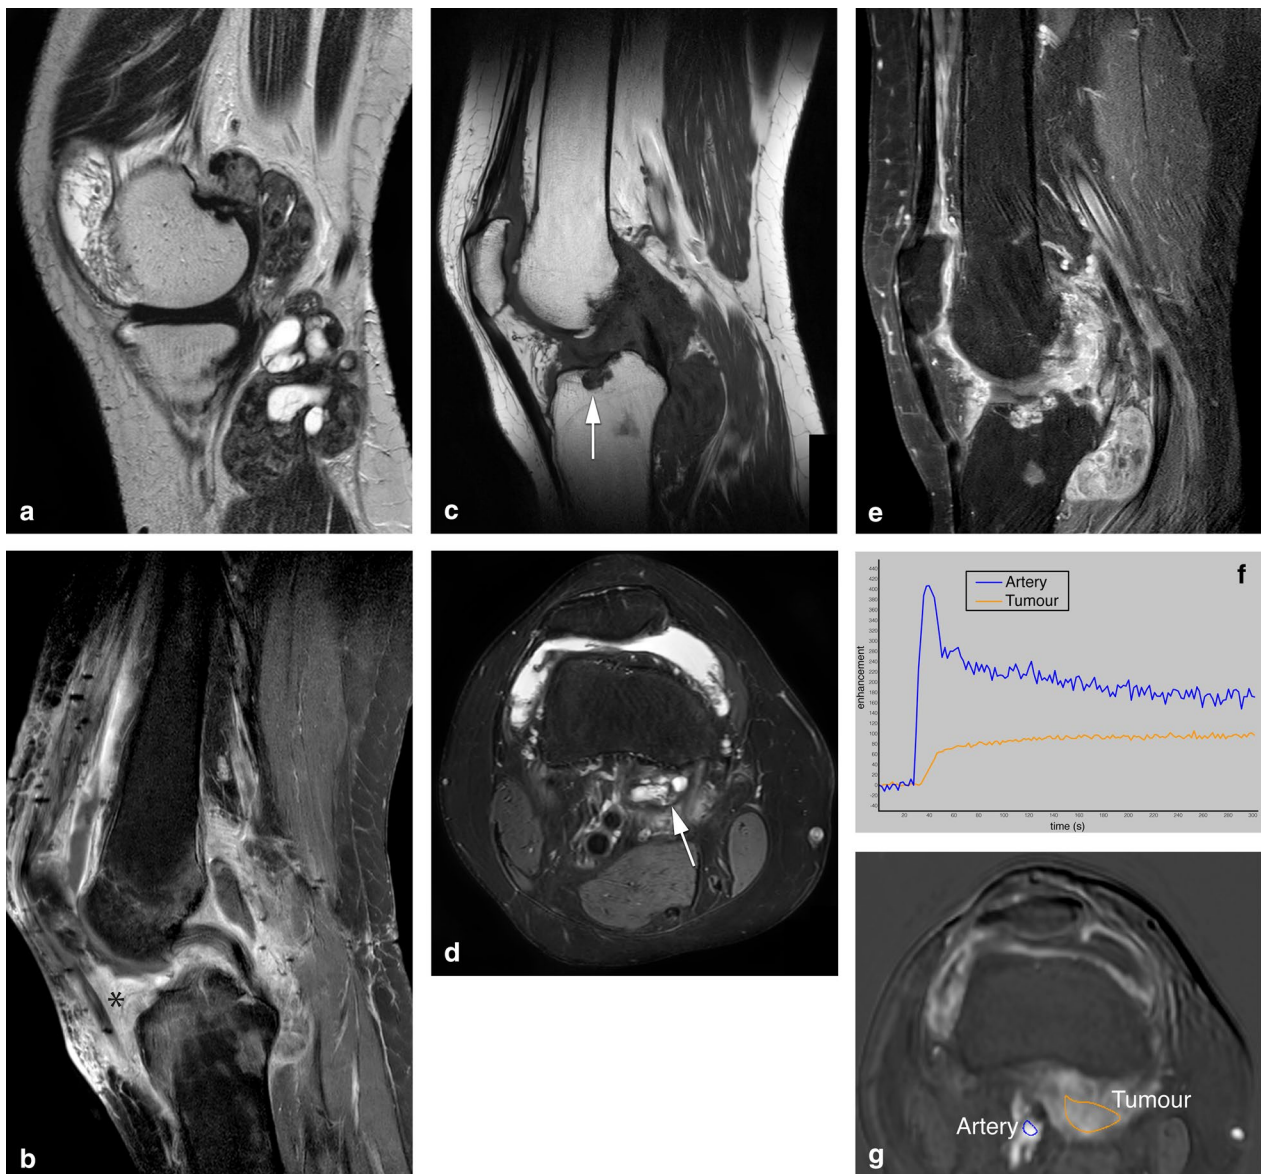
A case of D-TGCT demonstrating pre and post synovectomy findings on MRI. a Sagittal T2 weighted image shows multilobular posterior tumour with low signal intensity, and adjacent cyst-like components present within tumour in the popliteal cyst. Anterior, in the medial gutter of the suprapatellar recess smaller synovial proliferations are present. b Sagittal T1 SPIR post contrast performed 3 months after anterior and posterior synovectomy shows surgical clips with metal artefact anterior and posterior in the soft tissues, thickening of the quadriceps tendon, subcutaneous oedema and marked enhancement in Hoffa's fatpad (asterisk) and along the posterior cortex of the tibia (subpopliteal recess). This mass-like enhancement can be post operative but residual tumour cannot be excluded at this time. *MRI performed 3 years post synovectomy*: c Sagittal T1 shows a bone erosion centrally in the tibial plateau (arrow). Furthermore, soft tissue masses posteriorly in the knee are present containing foci of low signal intensity. d Axial PD SPAIR shows a typical location of a lesion containing cystic components at the medial retrocondylar recess (arrow). e Sagittal T1 SPIR post contrast demonstrates enhancement of tumour within the tibia plateau erosion and of the posterior mass lesions. Note that Hoffa's fat pad shows normalisation of fatty signal intensity except for a rim of tumour enhancement in the central synovial recess and inferior infrapatellar recess. f, g Time intensity curve of the tumour based on the region of interest (orange line) of the lesion demonstrated in d, showing early enhancement within 10 s after the artery (blue line) followed by a plateau phase (type III curve suggestive of a benign lesion)
